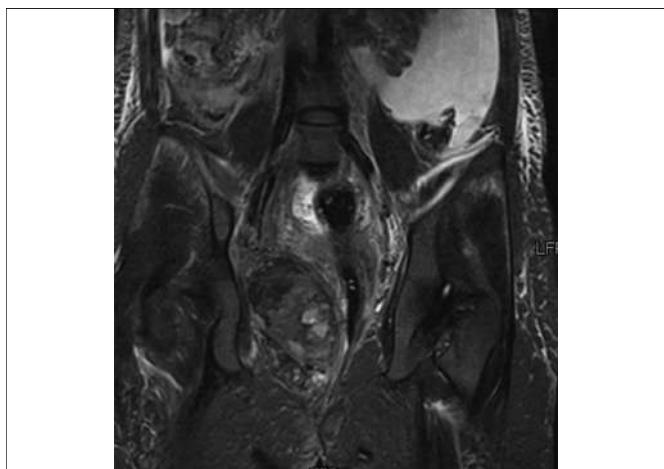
Coronal MRI image of the vulvo-vaginal hematoma.
